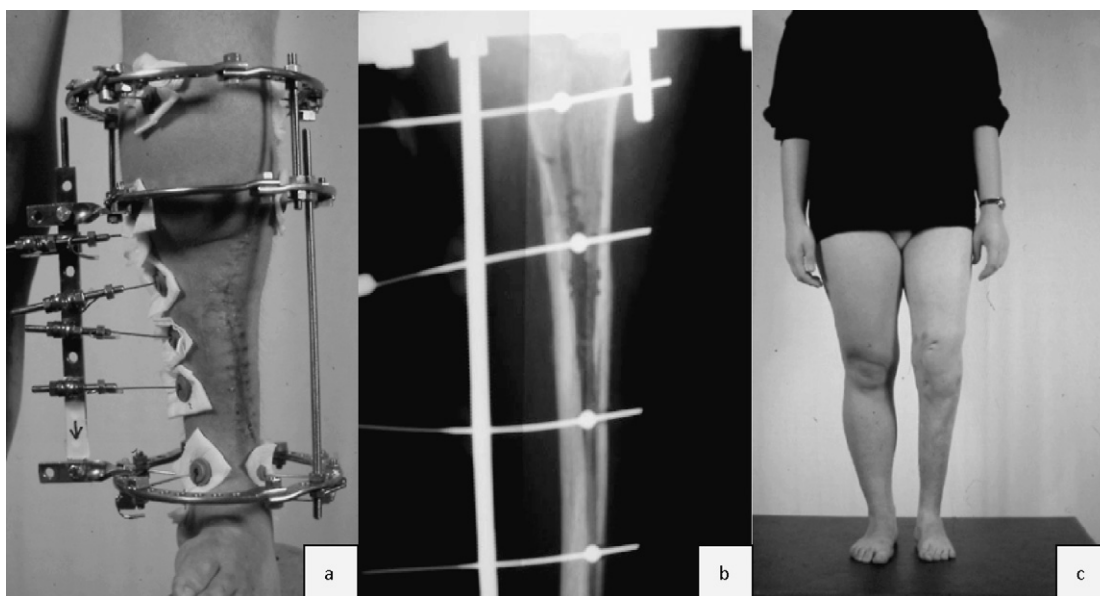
Congenital deficiency of the tibia type 1 (case n° 1); a: clinical and (b) radiographic aspect during transversal widening of the fibula with the Ilizarov fixator in the same patient; c: clinical aspect at maturity in the same patient.
